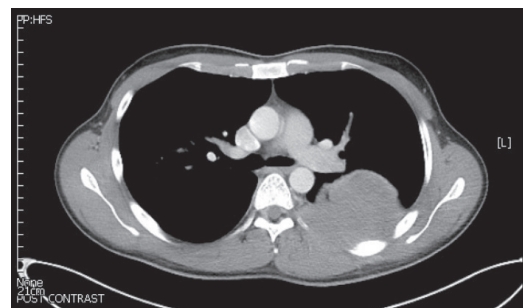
Computed tomography scan of the chest before the 4 courses of neoadjuvant concurrent chemoradiotherapy, showing the location of the chest.
